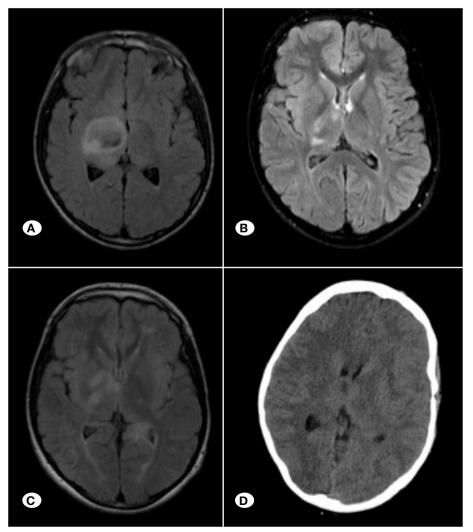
Neuroimaging findings of a 14year old male patient. Axial FLAIR image of initial MRI shows a right thalamic mass with central necrosis (A). 12 week after the operation and chemo-radiotherapy a marked resolution of the mass is seen with small residual hyperintense focus in the right thalamus and internal capsule (B). However, the FLAIR image obtained another 10 weeks later shows relapse of the right thalamic mass with swelling and extension as well as new cortical lesions in the contralateral parietooccipital lobe and insula (C). Axial CT of the patient obtained 3 months later shows progression of the left hemispheric infiltrating mass, now Iso involving the left thalamus and causing midline shift (D).
